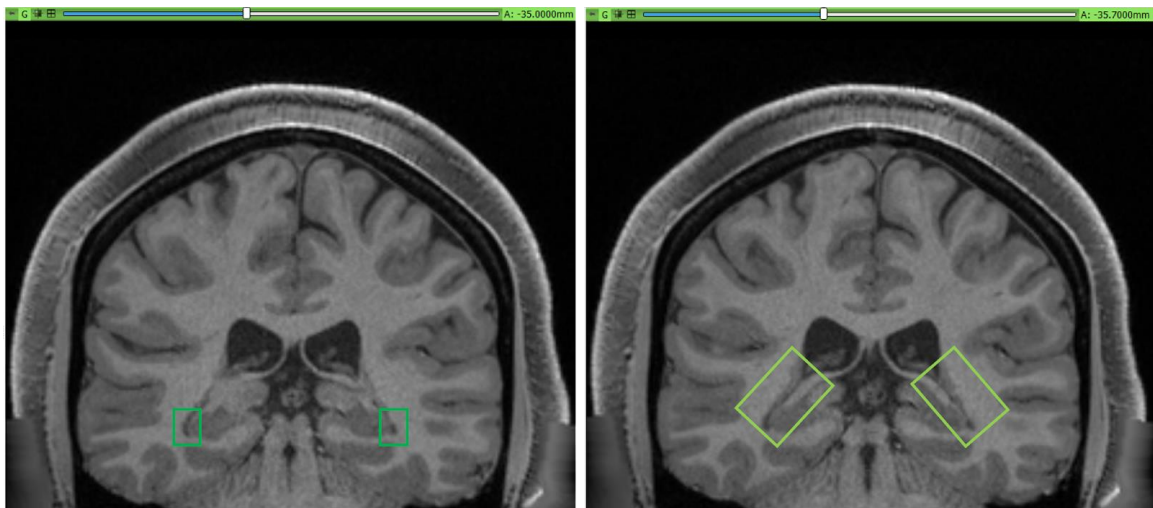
MRI imaging showing the transition from the body (left) to the atrium (right). Notice that in the left image, the superior body of the lateral ventricle does not extend inferolaterally to reach the space in the dark green box, whereas in the subsequent section on the right this extension is observed (light green box).
